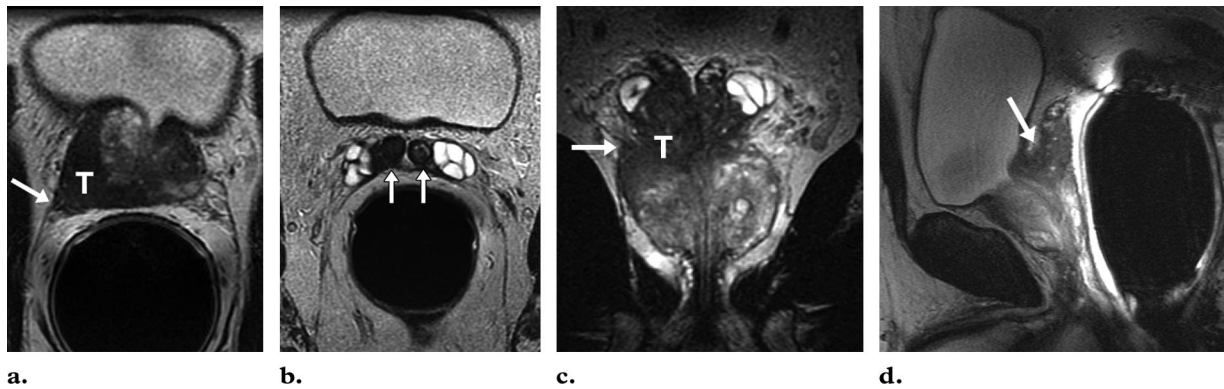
Biopsy-proved adenocarcinoma in a 61-year-old man. (a, b) T2-weighted axial MR images obtained at the level of the base of the prostate (a) and at the seminal vesicles (b) show a low-signal-intensity tumor (*T*) in the base of the right lobe with extracapsular extension (arrow in a) and invasion into the seminal vesicles bilaterally (arrows in b). (c) T2-weighted coronal image shows asymmetry of the right and left lateral aspects of the base, with an angulated contour of the right base (arrow), a finding that is highly suggestive of extracapsular extension of the tumor (*T*). (d) On the T2-weighted sagittal MR image, the fat plane between the seminal vesicle and the posterior urinary bladder is obliterated (arrow). The angle made by the posterior bladder wall and the anterior border of the seminal vesicles is more convex than that seen in healthy men (cf Fig 1i).
